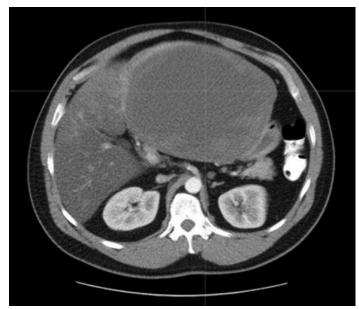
CT Scan s/p Imatinib Therapy
